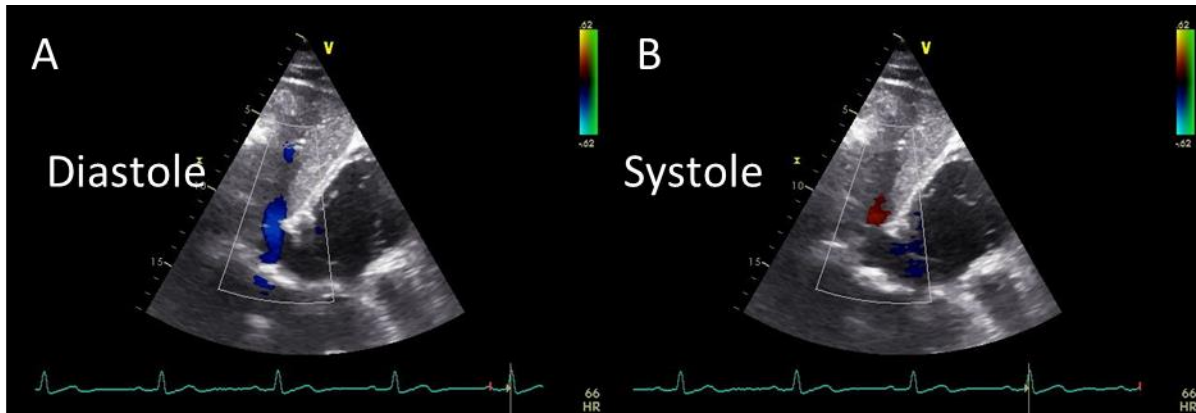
Subcostal echo in a person with tricuspid regurgitation, color Doppler of the hepatic vein in diastole and systole shows systolic flow reversal (red), alternatively with positioning of the PW Doppler in the hepatic vein there is also evidence of retrograde systolic flow
